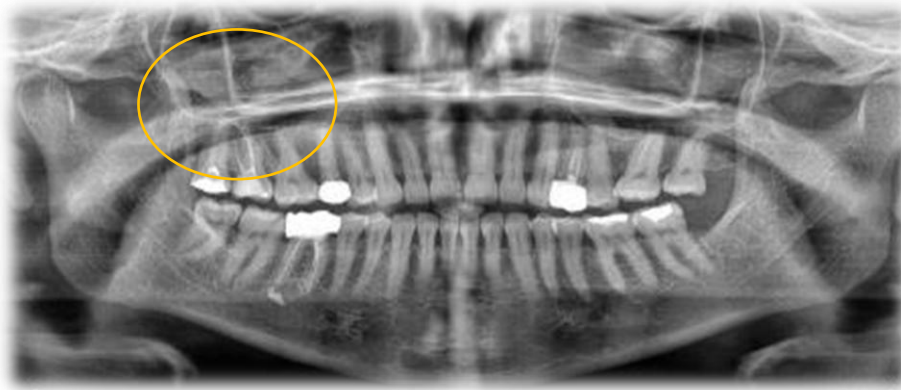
Panoramic radiograph (OPG) clearly depicts a dome-shaped radiopacity in the right sinus, consistent in location and morphology with the CBCT finding.
